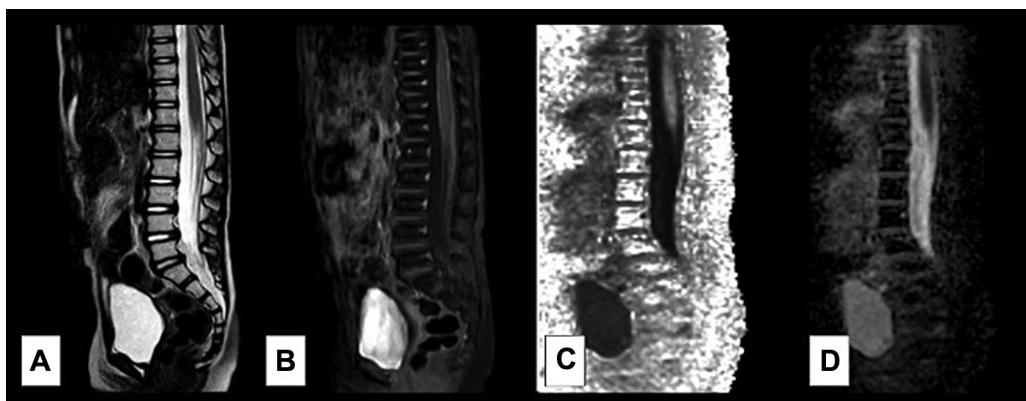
Smooth leptomeningeal metastasis: case of SHH medulloblastoma in a 5-year-old child shows linear enhancement along the cauda equina on post-contrast image (B). This is not appreciated on T2W (A) and diffusion images (C, D). SHH, Sonic Hedgehog; T2W, T2-weighted.
